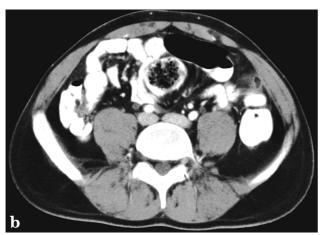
a) Non-enhanced and, b) enhanced CT demonstrate hypodense lesion on the left side, anterior to the descending colon, and increased density of mesenteric fat planes around the lesion. The lesion had fat density centrally with peripheral contrast enhancement, c) Follow-up non-enhanced CT scan shows regression of findings
